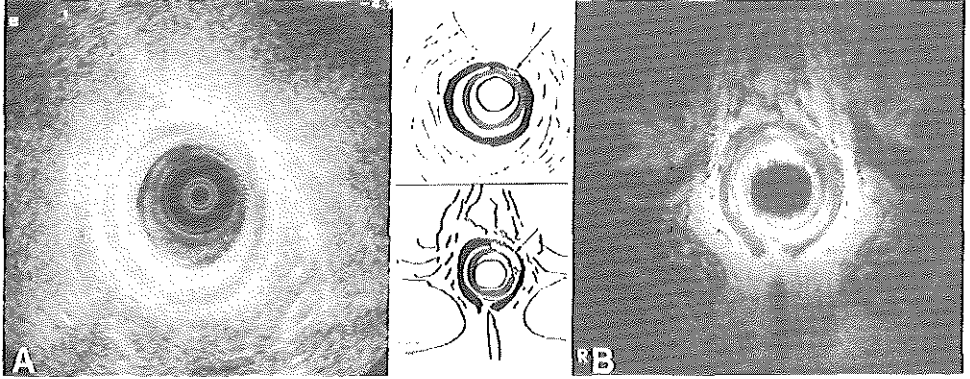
Localized scarring.* Axial sonography (A) and MRI (B) in a male (37) with faecal incontinence after hemorrhoidectomy. Note the deformation of the external sphincter (arrow) left anteriorly due to the presence of scar tissue.
